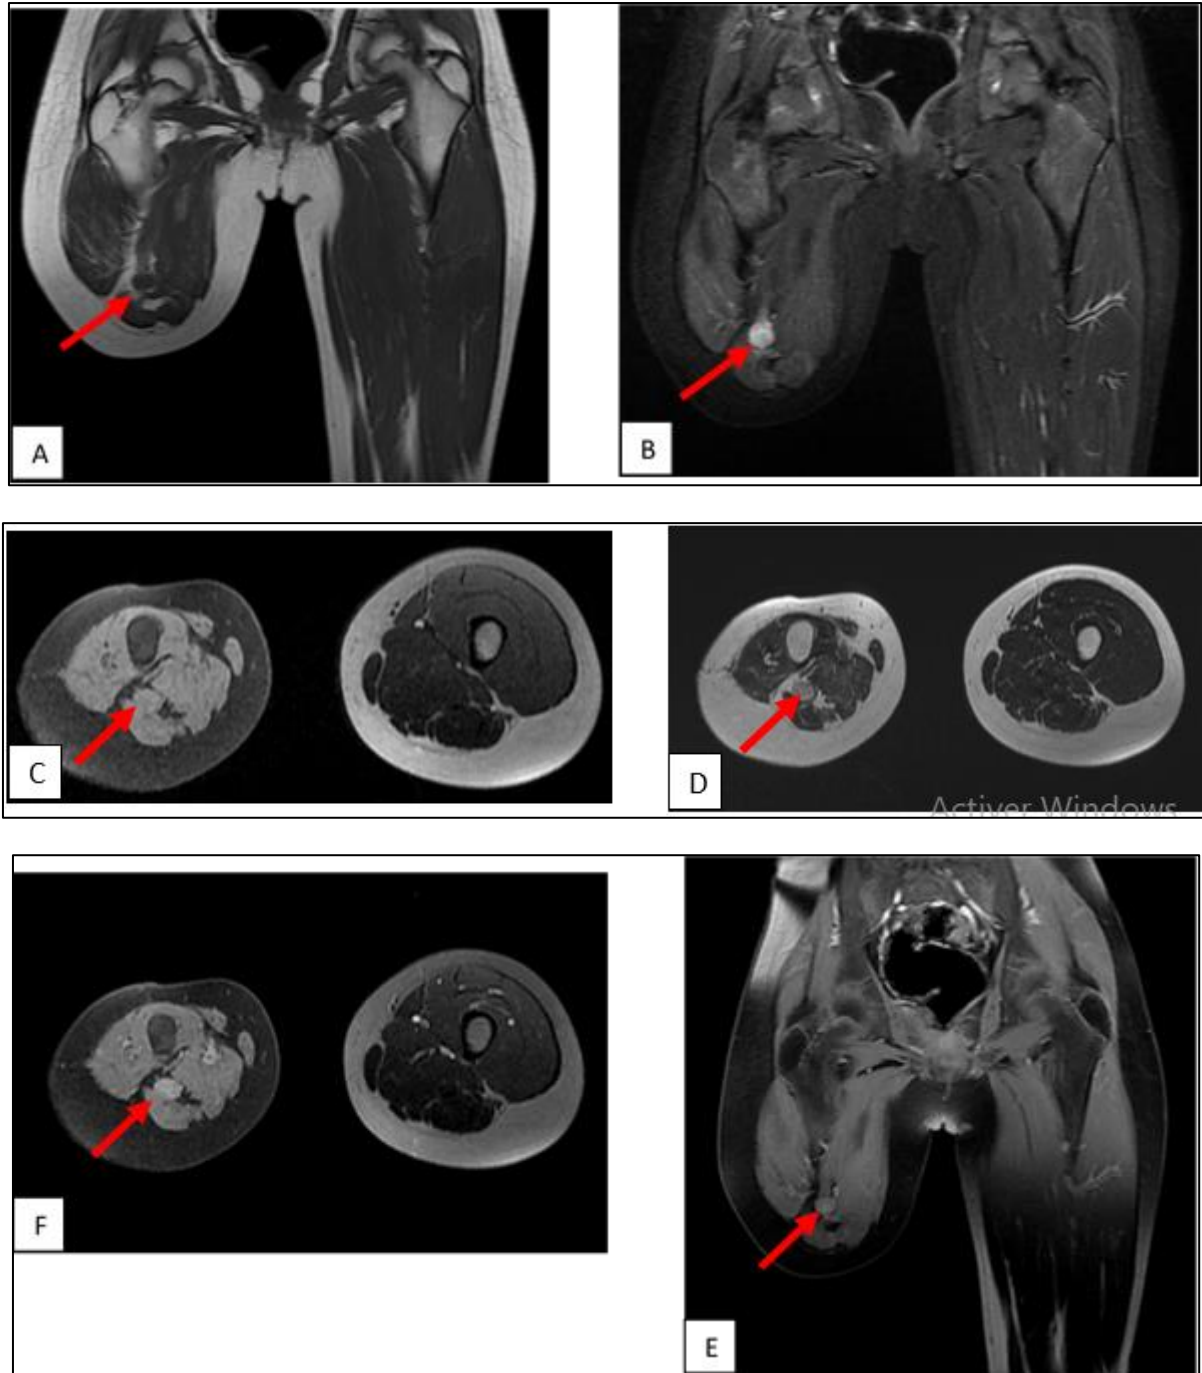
Coronal T1-weighted (A), coronal STIR (B), axial fat-suppressed T1-weighted (C), axial T2-weighted (D), axial contrast-enhanced fat-suppressed T1-weighted (E), and coronal contrast-enhanced fat-suppressed T1-weighted (F) MR images obtained after CT demonstrate a well-defined ovoid lesion arising from the distal sciatic nerve (red arrow). The lesion is isointense to muscle on T1-weighted images and shows intermediate-to-high signal intensity with a fascicular pattern on T2-weighted images, with homogeneous post-contrast enhancement
